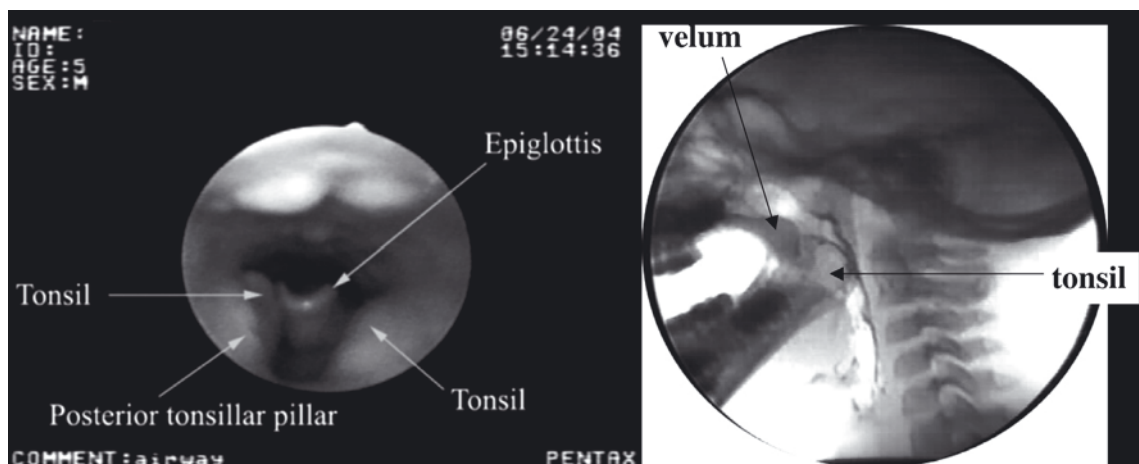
Hypertrophic tonsils seen endoscopically and on lateral view radiographs showing that they intrude posteriorly into the pharyngeal airway behind the faucial pillars
